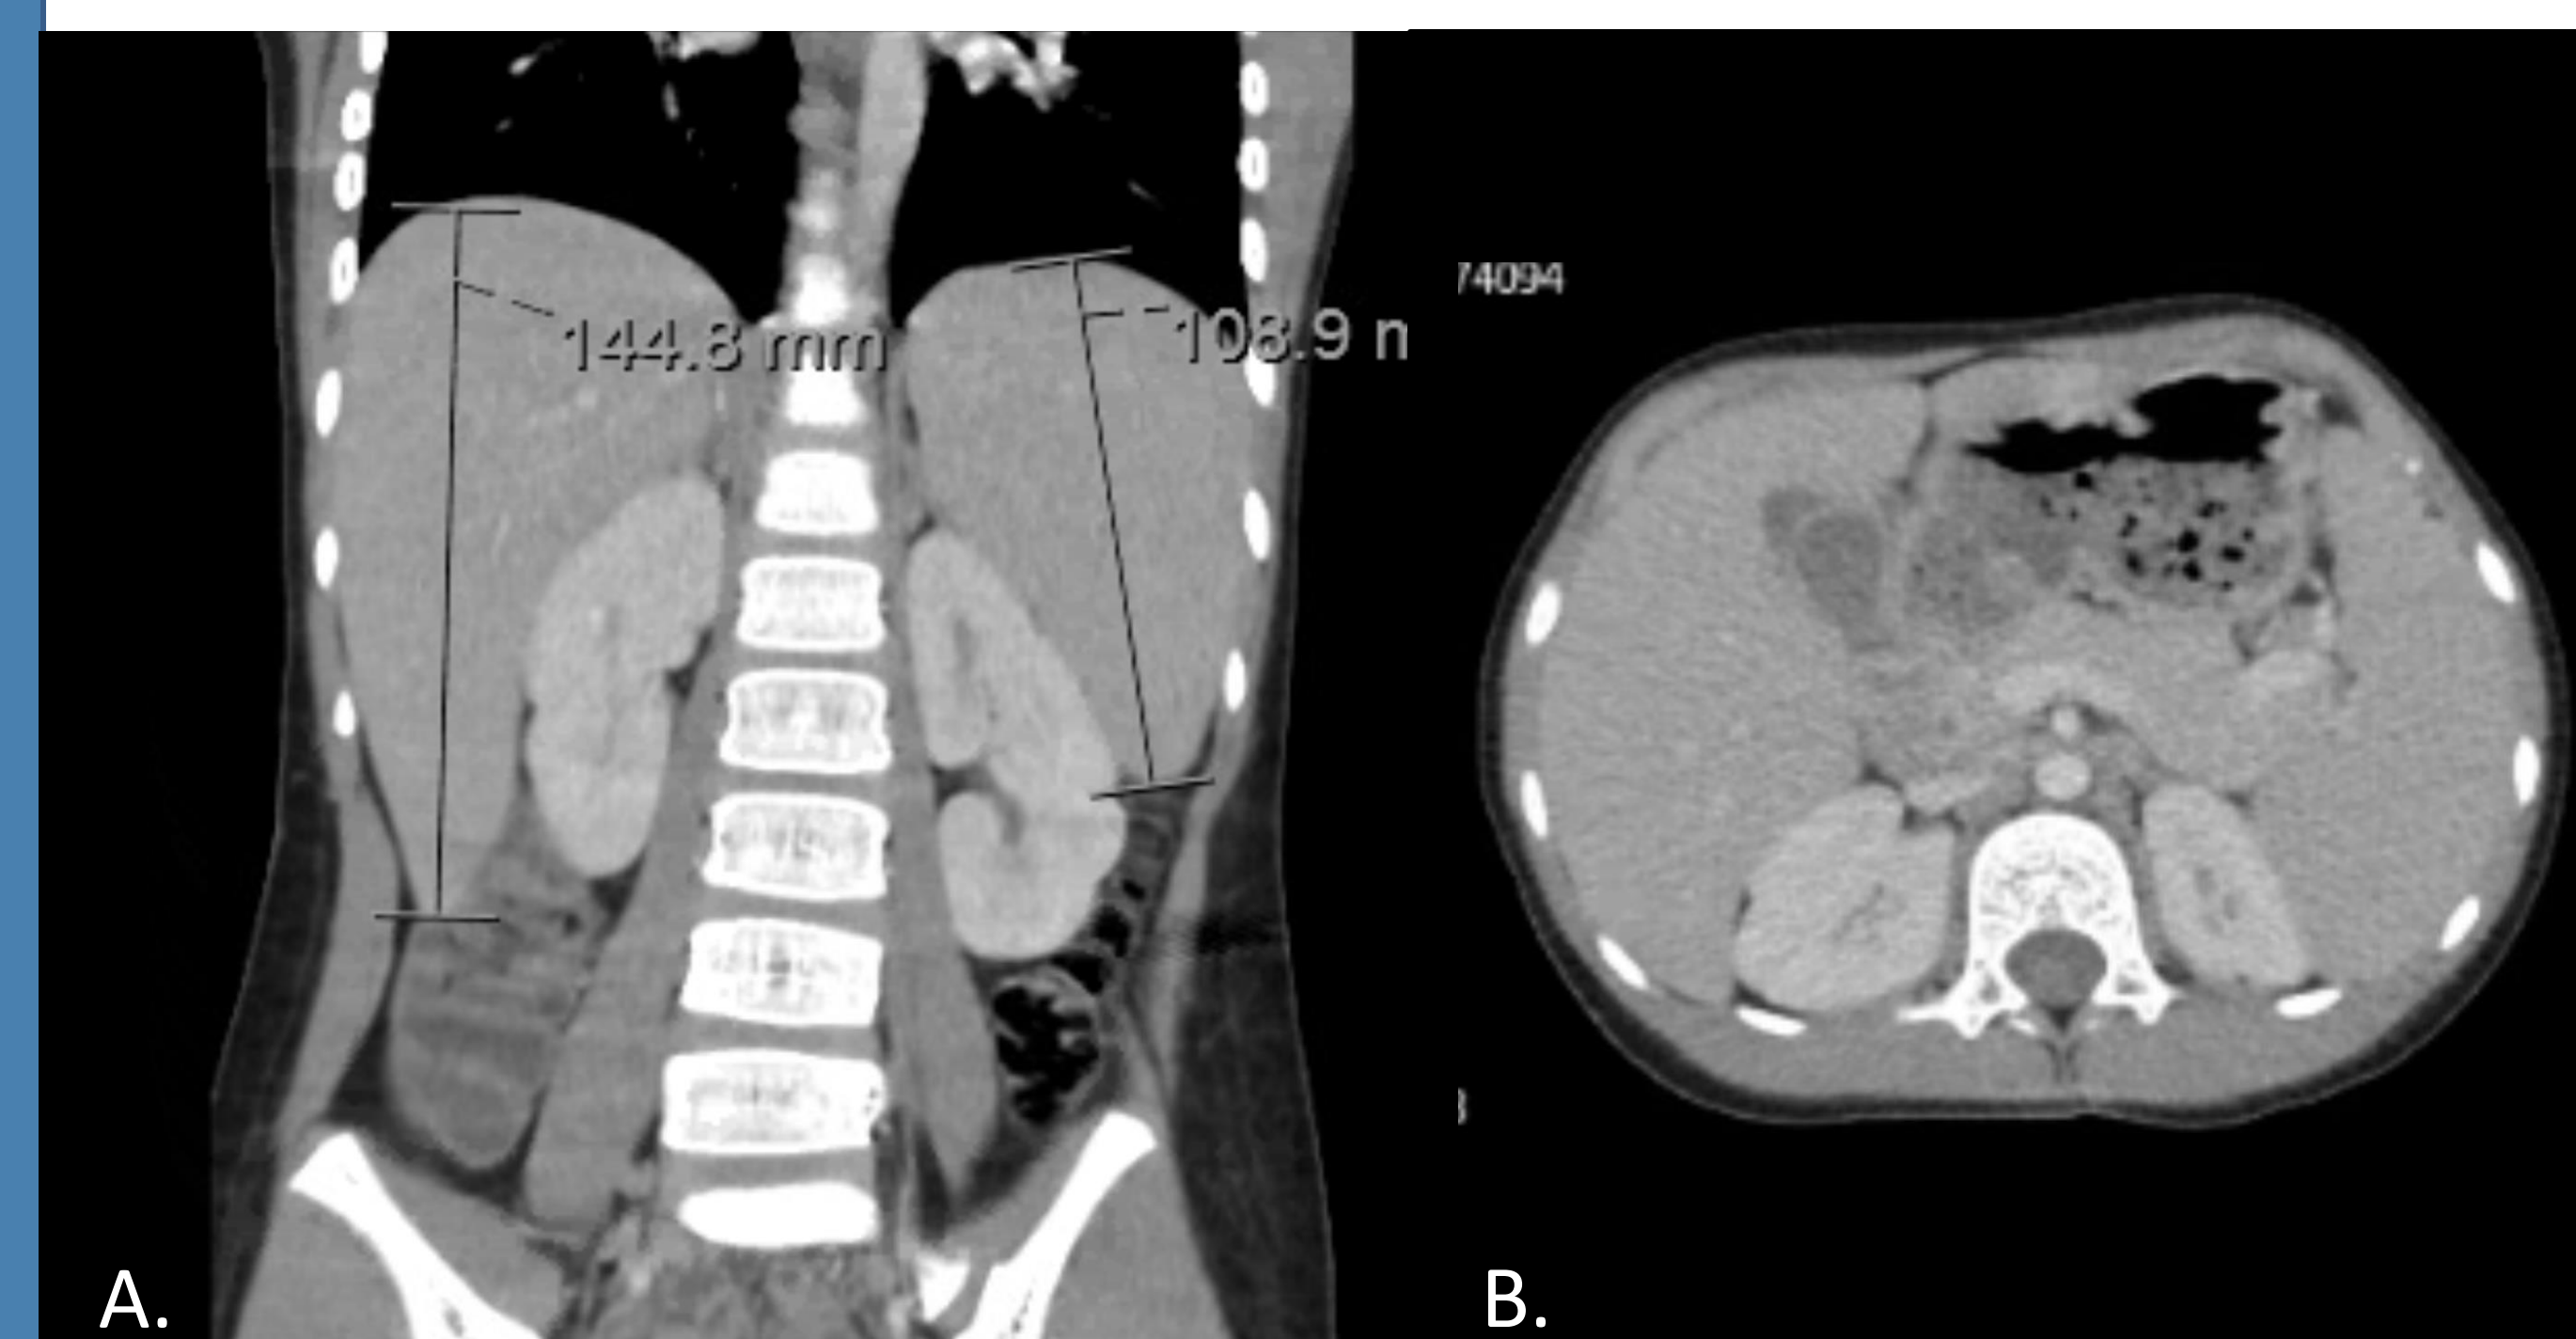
CT Abdominal and Pelvis with contrast taken on admission. (A) shows hepatosplenomegaly; (B) shows pericholecystic fluid, gallbladder with no echogenic stones.
